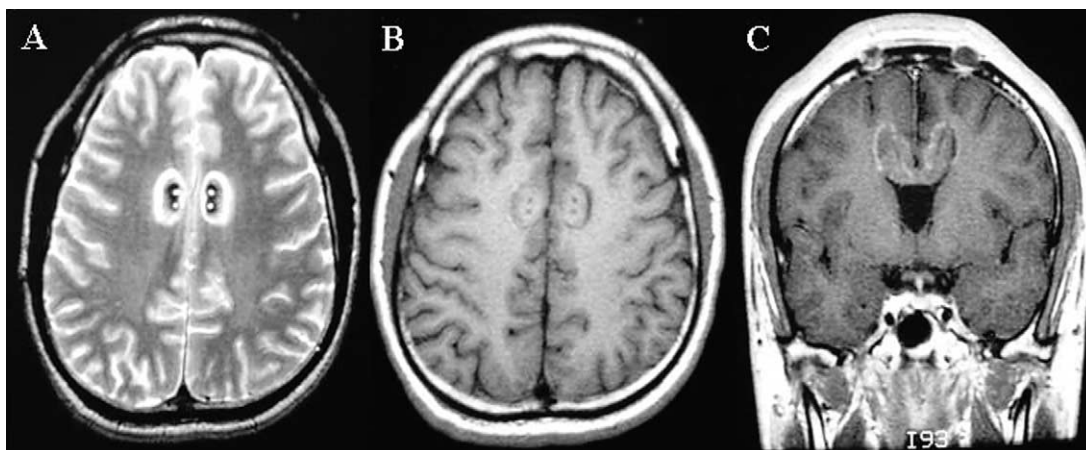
T1- and T2-weighted MRI 3 months after cingulotomy demonstrated the resolved perilesional edema along the radiofrequency lesions. Lesions were confined in the anterior cingulate gyrus. (A) T2-weighted axial image. (B) T1-weighted axial image. (C) The coronal image.
